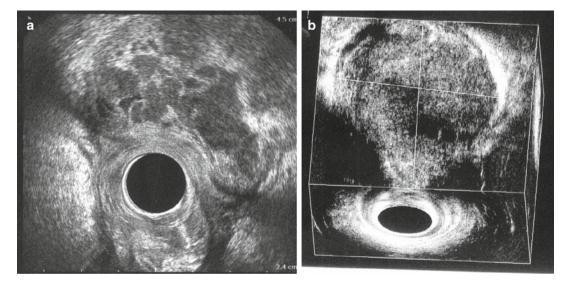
Three-dimensional endorectal ultrasound performed with 2050 transducer (B-K Medical). Female patient. Large mixed echogenicity angiosarcoma with anechoic area inside (vascular structures) located at the level of lower rectum in the anterior quadrant. The lesion is located in the perirectal fat and involves the rectal wall as far as the muscular propria. (a) Axial plane; (b) coronal plane
